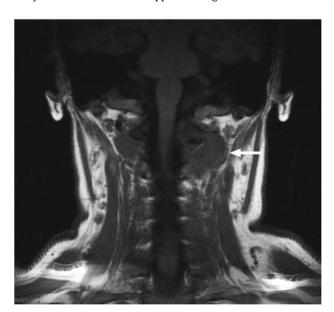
T1-weighted MRI showing the lesion in the posterosuperior aspect of the left neck arising at the level of C1, eroding through the C1 vertebra and displacing the thecal sac
